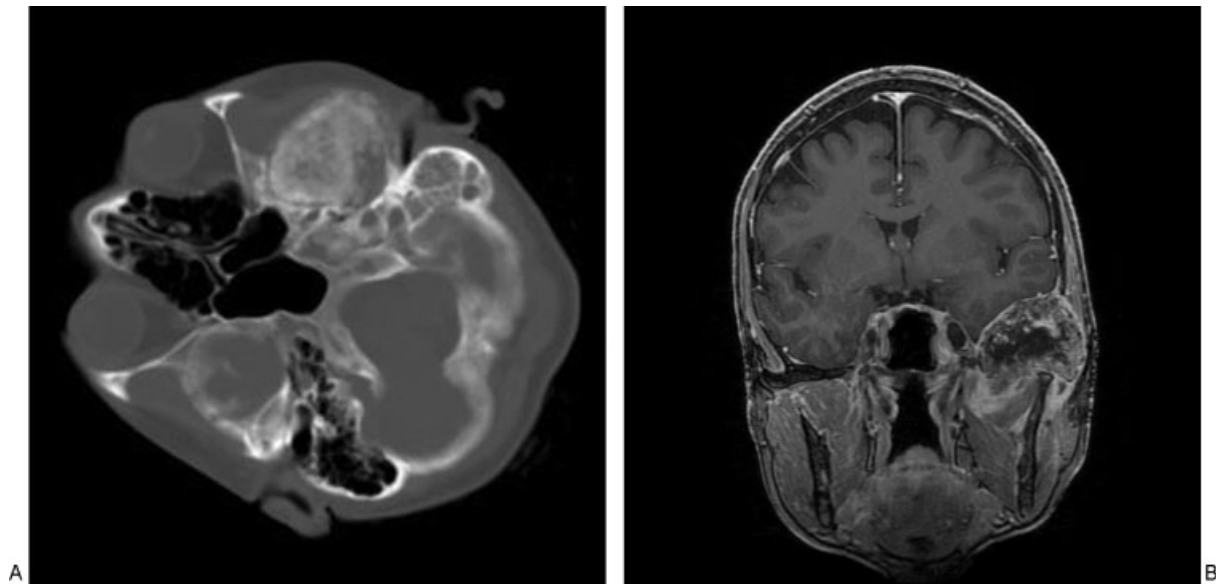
(A) Axial computed tomography scan demonstrating left temporomandibular joint (TMJ) erosion by a calcified lesion. (B) Coronal postcontrast T1-weighted magnetic resonance imaging demonstrating erosive lesion at the left TMJ.
